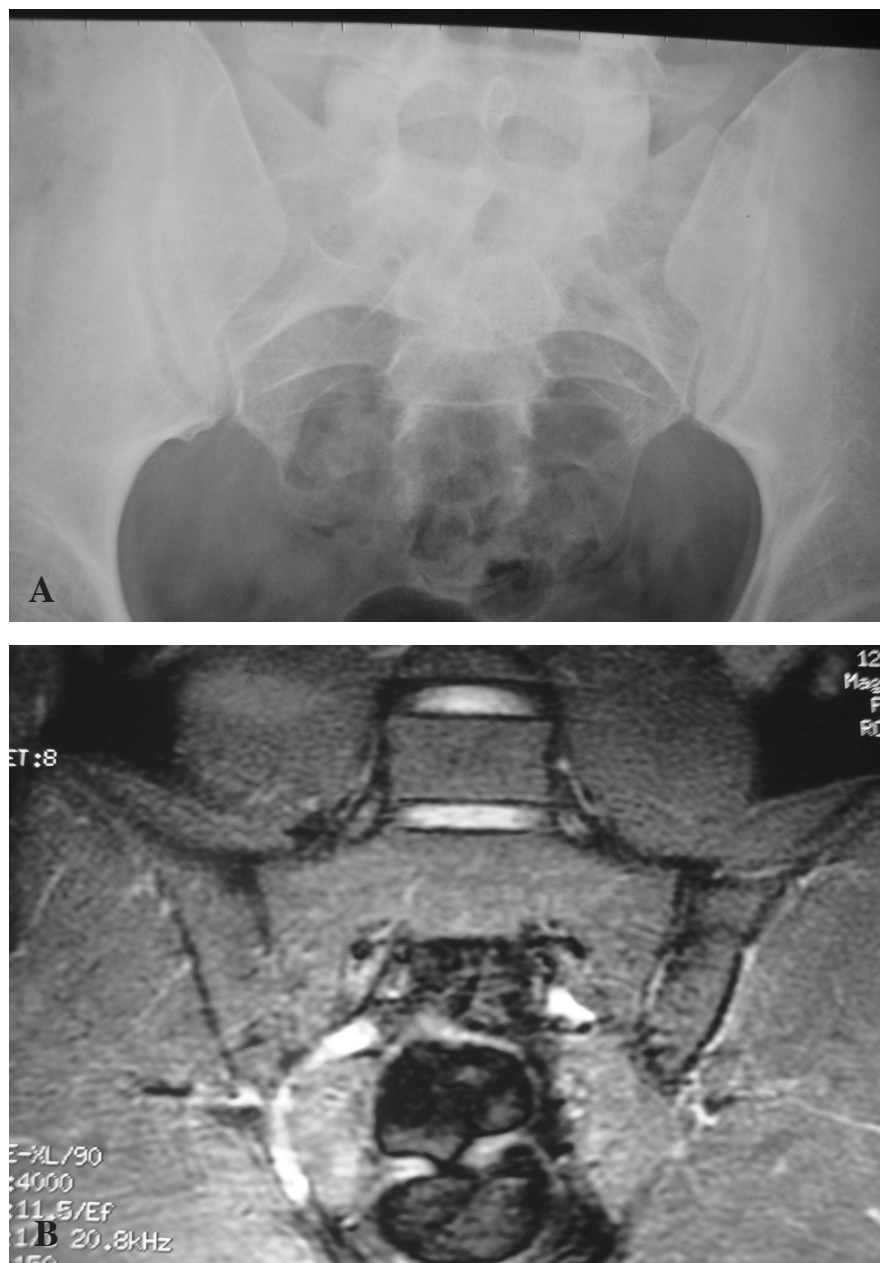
Images of patient n. 4 obtained at the 5th year evaluation. A) Antero-posterior view of the pelvis showing normal sacroiliac joints. B) STIR MRI showing the disappearance of the bone oedema.
